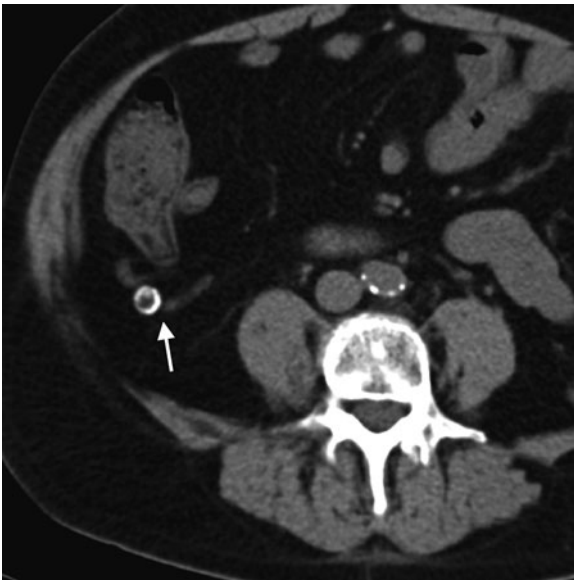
Transverse unenhanced CT image demonstrates a normal appendix with a large appendicolith
